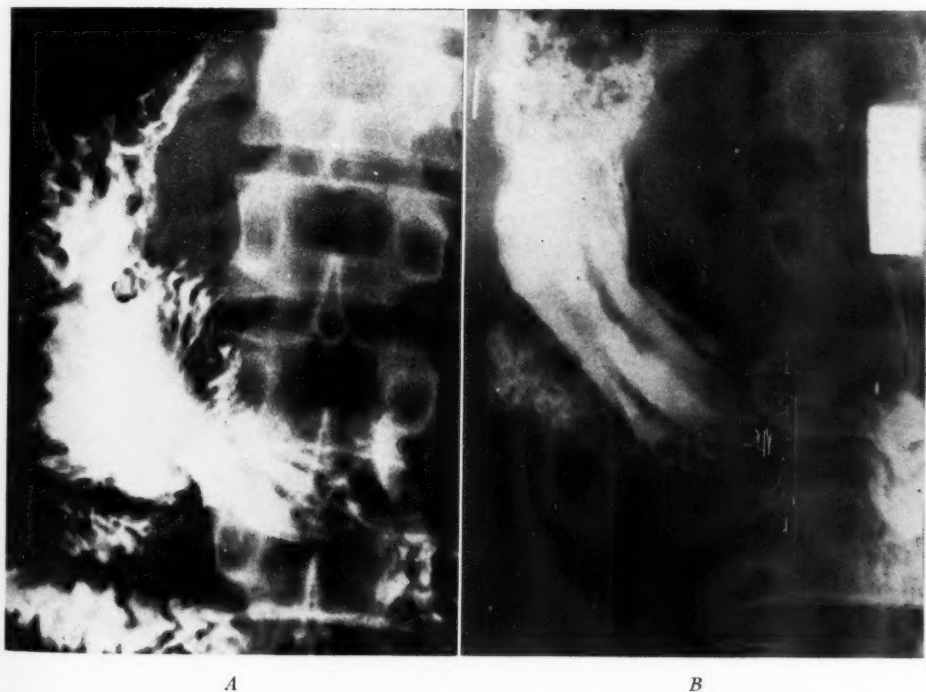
Roentgenologically normal mucosal pattern but diagnosed at gastroscopy as a case of erosive gastritis.
